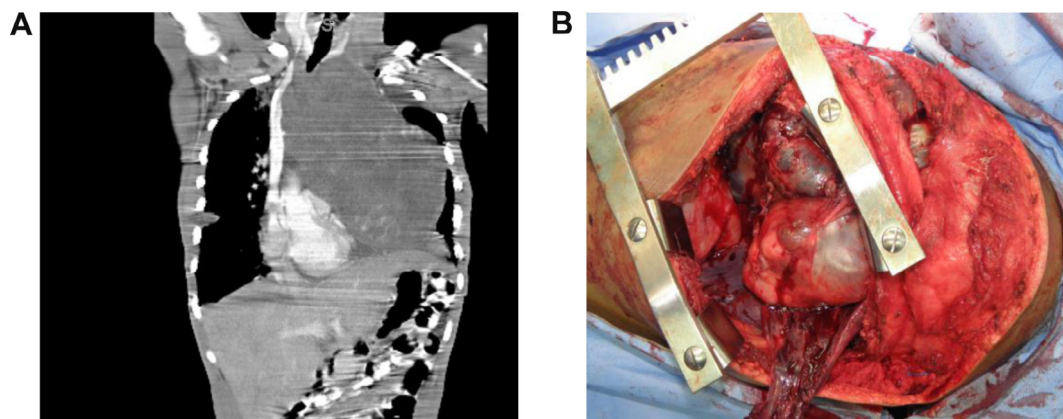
(A) CT Coronal view of mediastinal GCT. (B) Intraoperative view of Double level thoracotomy approach.
